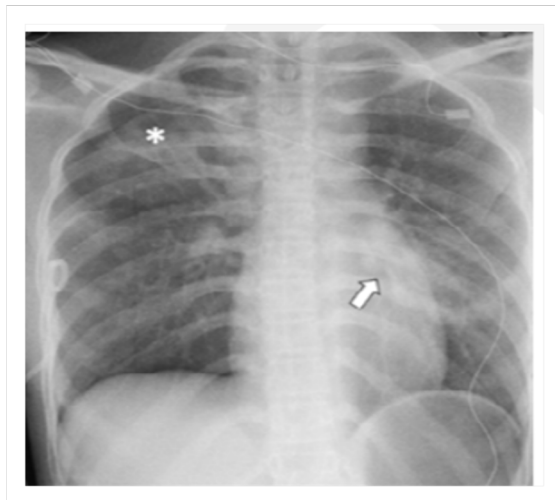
9-year-old female with renal transplant and positive COVID-19 RT-PCR test who presented with respiratory distress. Frontal chest radiograph shows consolidation (asterisk) in the left lower lobe, which is atypical for pediatric COVID-19 pneumonia.⁷⁶
